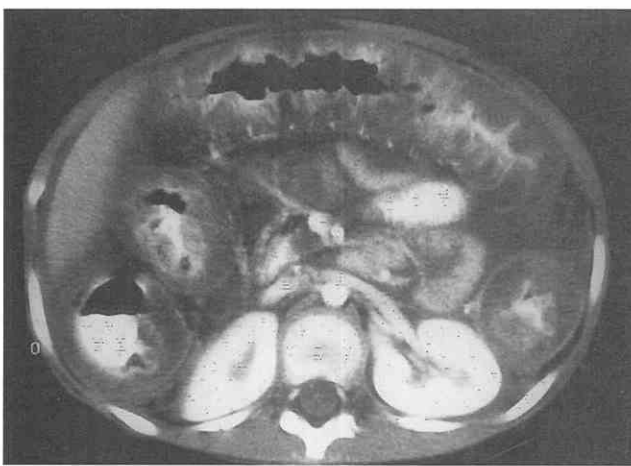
Pseudomembranous colitis. CT scan through the midabdomen in a patient with pseudomembranous colitis shows contrast material trapped between thickened haustral folds, a finding that has been labeled the "accordion sign."
